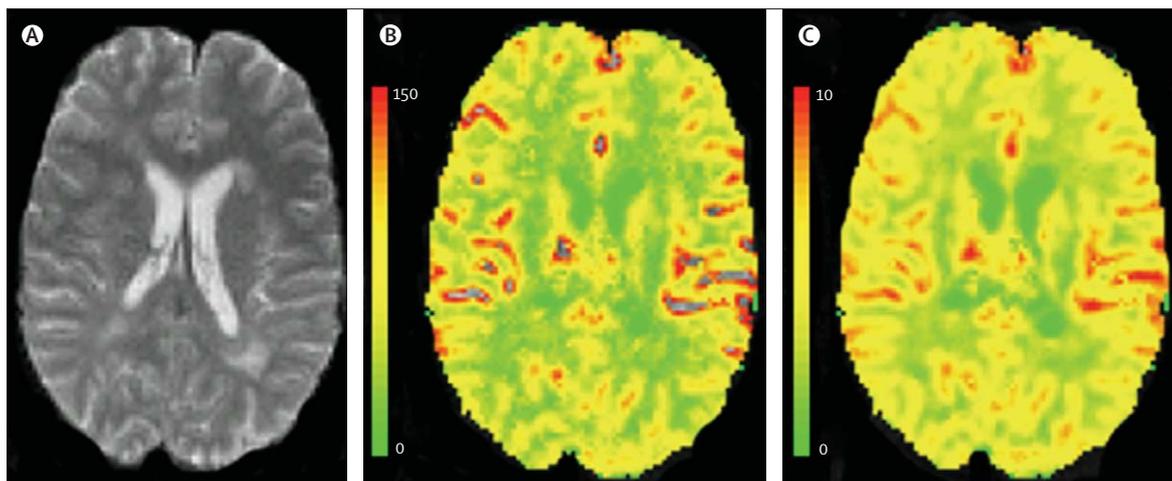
Axial gradient-echo echo-planar MRI showing cerebral blood flow and volume in a patient with MS (A) Axial gradient-echo echo-planar MRI, (B) colour-coded cerebral blood flow map, and (C) colour-coded cerebral blood volume map from a patient with MS. The colour bars indicate the cerebral blood flow (mL/100 g/min) and the cerebral blood volume (mL/100 g).
